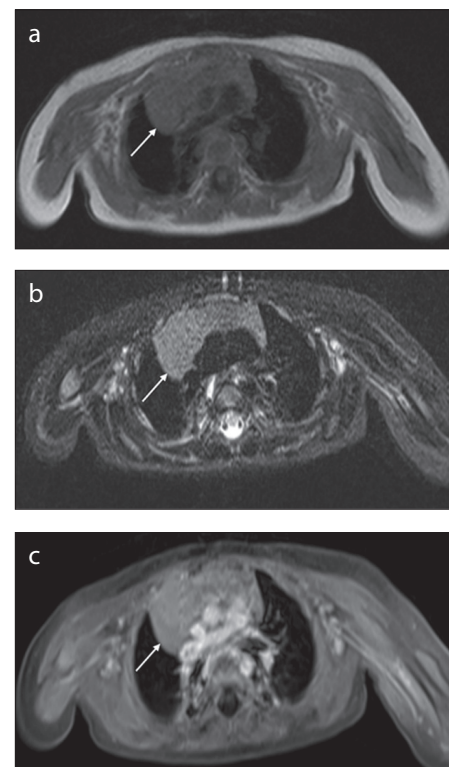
a-c. An 11-year-old male with pathologically confirmed thymoma in the anterior mediastinum. Axial T1-weighted image (a) reveals hypointense thymoma lesion (white arrow). Axial T2-weighted image (b) reveals hyperintense thymoma lesion (white arrow). Axial postcontrast-enhanced T1-weighted image (c) reveals no contrast enhancement in the thymoma lesion (white arrow).
